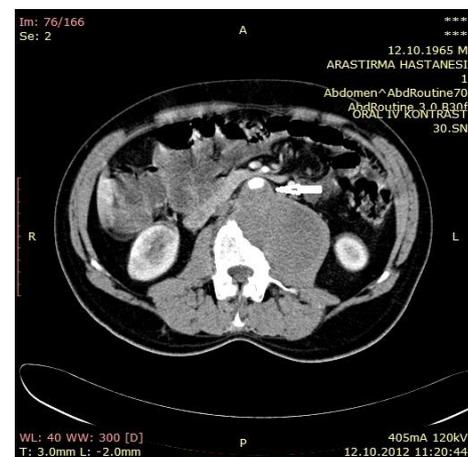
An axial contrast-enhanced CT image showing a partially thrombosed aneurysm (arrow), extending posterolaterally and compressing the left psoas muscle.
